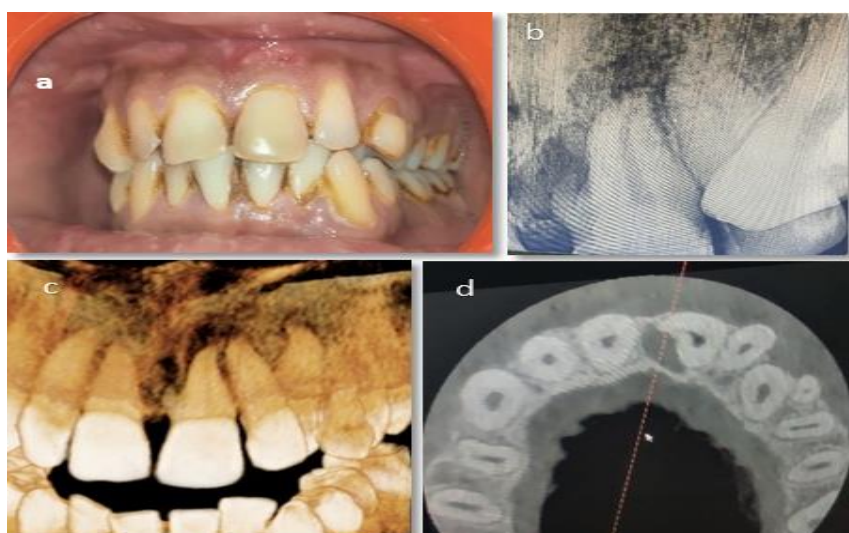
Preoperative a): intra-oral photograph; b): intra-oral radiograph; c): Cone beam computed tomography (CBCT) showing the left maxillary central incisor with supernumerary root attached near the cemento-enamel junction at mesial aspect of tooth; d): Axial image of cone-beam computed tomography scan showing the presence of radiolucency on mesial aspect of left maxillary central incisor.
